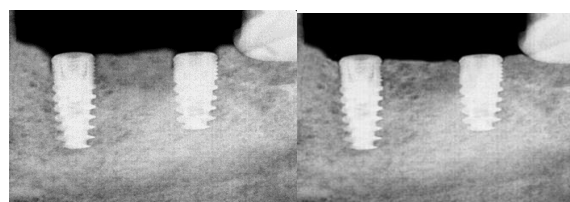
a) Immediate Post operative intra-oral periapical radiograph (b): 3-months post-operative intra-oral periapical radiograph.
